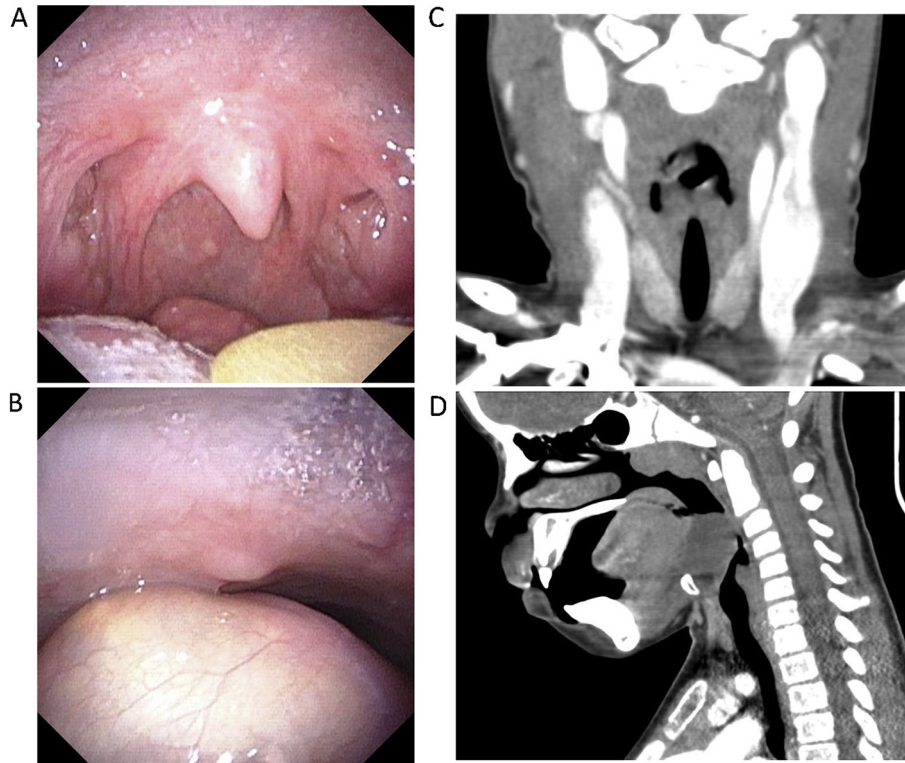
Preoperative clinical and radiological assessment of a lingual thyroglossal duct cyst in a child. A) A midline base of tongue mass is seen when the child's tongue is depressed. B) This mass abuts the soft palate when the child is resting without tongue protrusion. C) Coronal cut of a CT scan with contrast that revealed orthotopic thyroid tissue in the child. D) A $2.1 \times 1.9 \times 2.5$ cm hypodense mass is visualized at the base of tongue in this sagittal cut of a CT scan with contrast.
